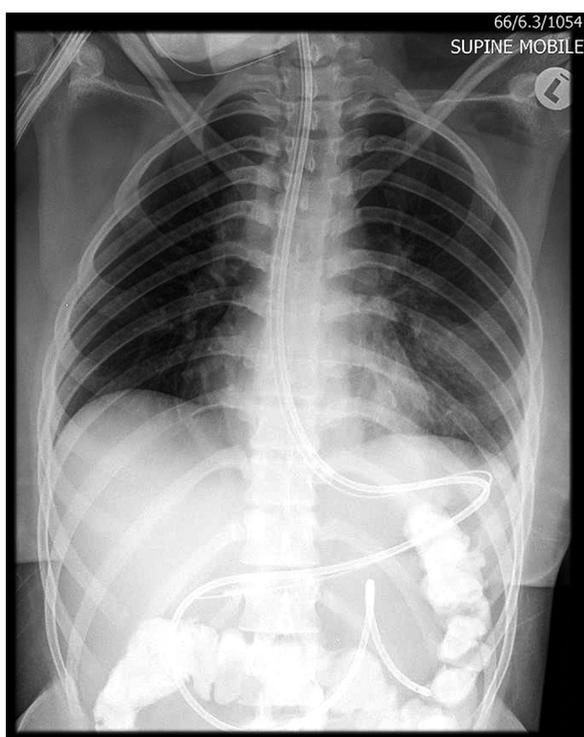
Plain abdominal X-ray post endoscopic placement of a nasojejunal tube confirming placement into the proximal jejunum (image includes a nasogastric tube and colonic contrast).
